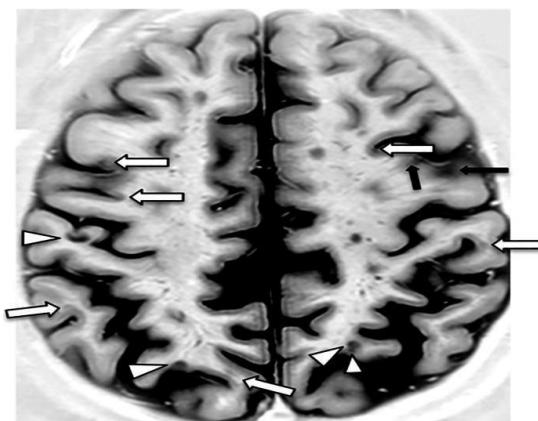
Axial PSIR MRI of a brain with multiple sclerosis lesions
